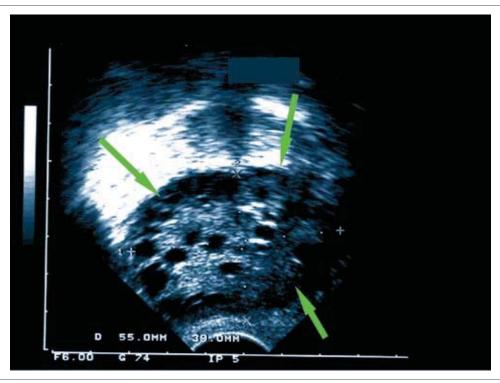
The ultrasonographic aspect of micropolycystic ovary
